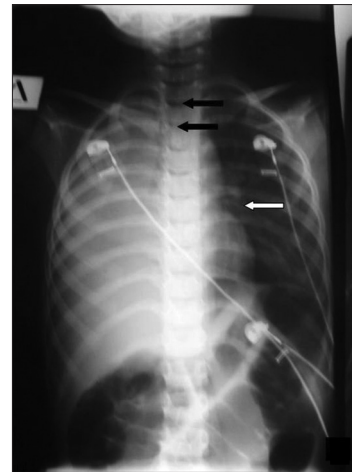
Chest radiograph showing tracheal deviation (black arrows), mediastinal shift (white arrow), left-sided hyperinflation, and low lung volumes and diffuse haziness on the right consistent with atelectasis
